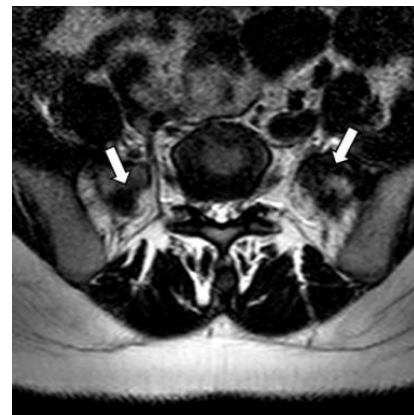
Bilateral sacralization and pseudoarticulation of L5 vertebra with sacrum is seen on axial T2-weighted MR image.
